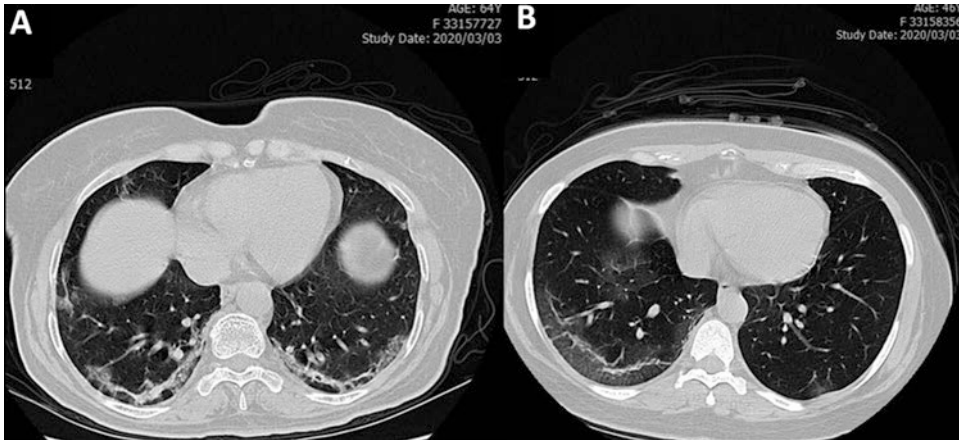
Two axial chest CT scans without contrast in (a) a 64-year-old female and (b) a 46-year-old male with COVID-19 pneumonia subpleural linear opacities and ground-glass opacities (GGOs)
